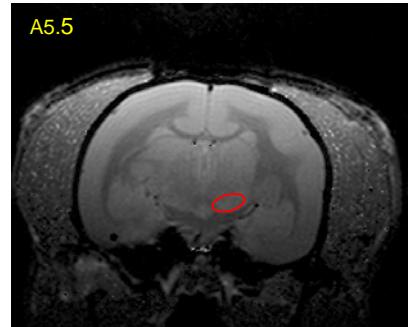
Example of a slice of the marmoset brain by MRI. The ROI of substantia nigra is shown in red.
